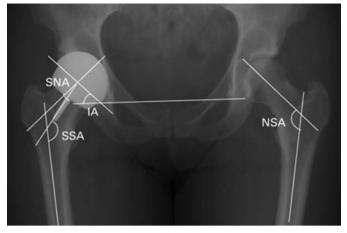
AP radiograph hip demonstrating MoM hip angles. Neck shaft angle (NSA), Stem neck angle (SNA) and stem shaft angle (SSA)
